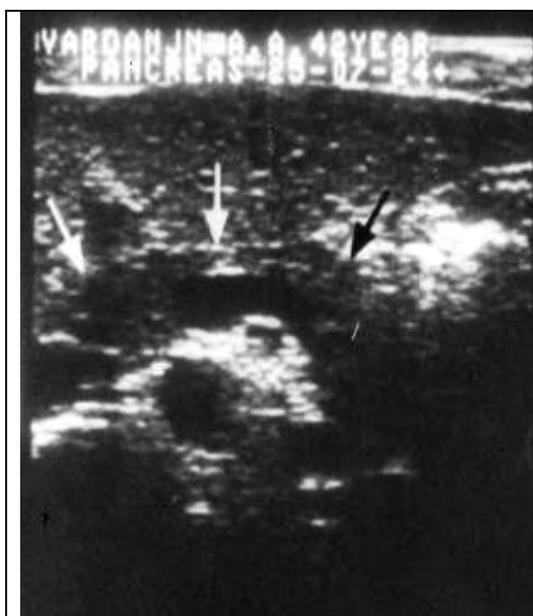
Normal pancreas ultrasound.
